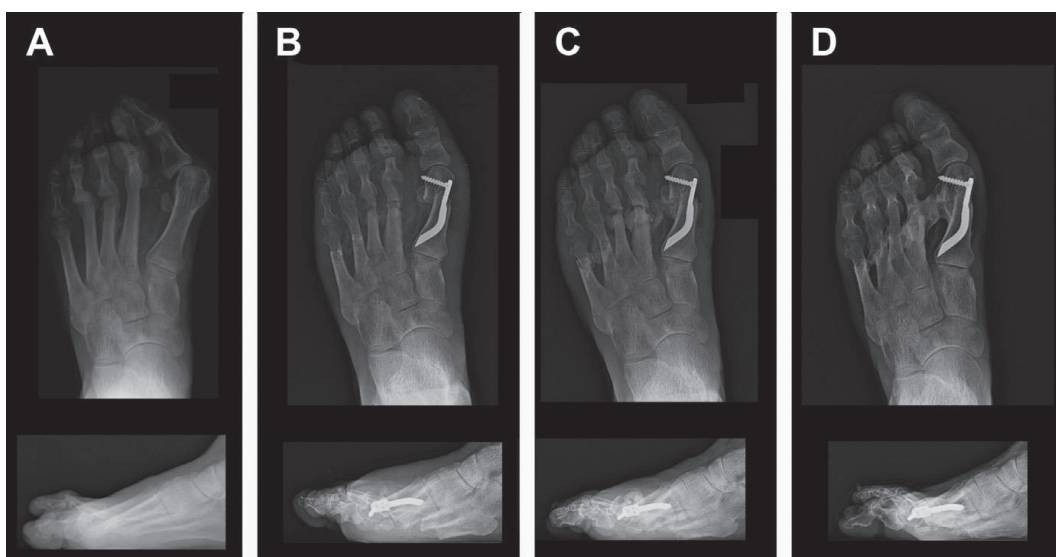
Case 3: radiographic images at (A) preoperative, (B) 1-month, (C) 3-month, and (D) 52-month follow-up.
